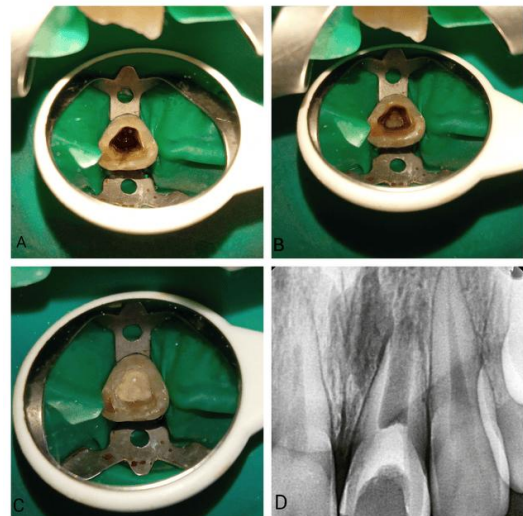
A: Bleeding induced in canal; B: PRF membrane placed in canal till level of CEJ; C: Biodentine placed in canal leaving 3-4 mm space coronally; D: Periapical radiograph during second appointment
